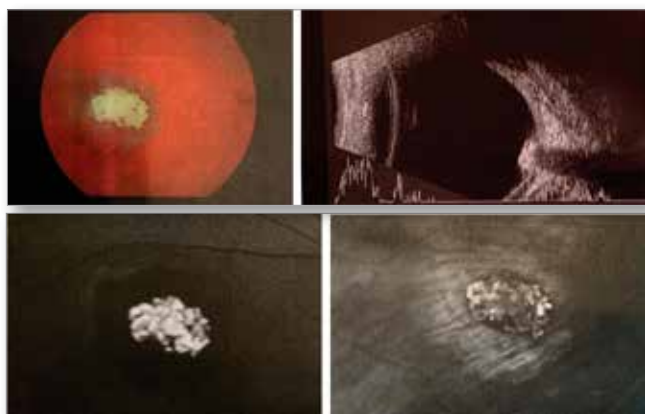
Retinocytoma: colour picture, ultrasound, autofluorescence and infrared examination.
